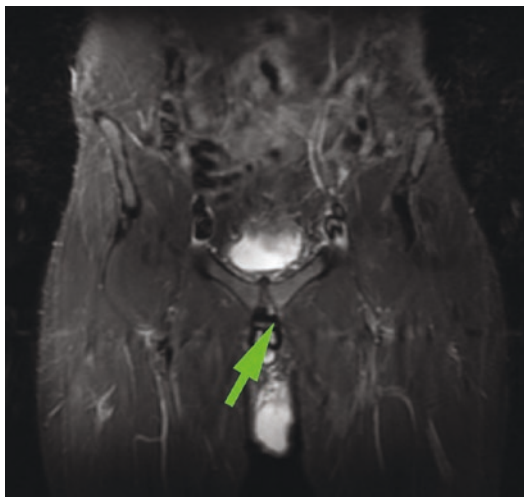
MRI Imaging of left osteitis pubis with adductor tendinosis
